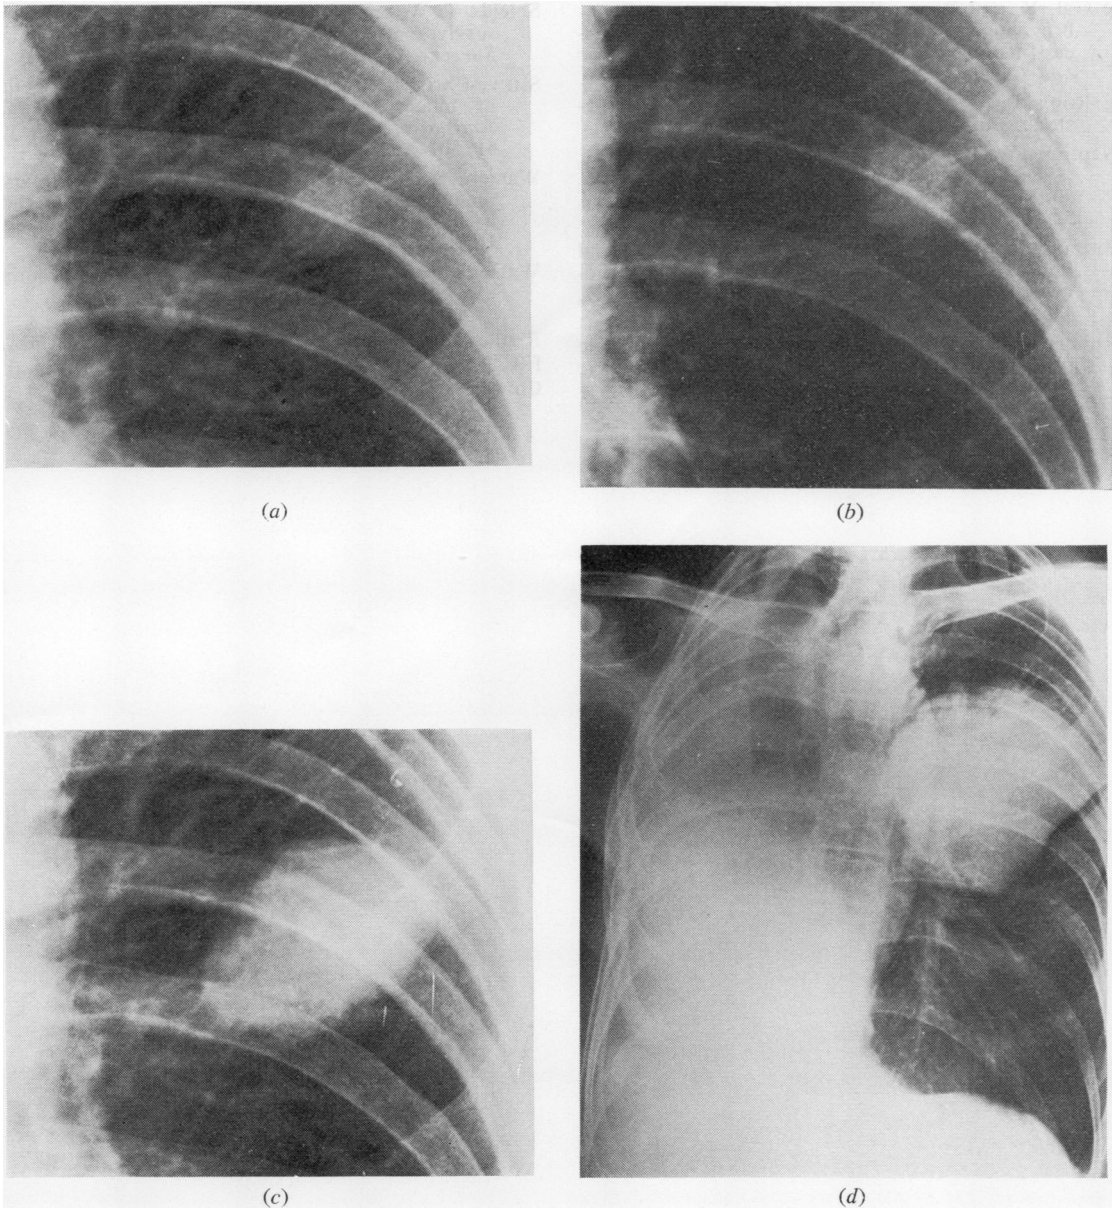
(a) Case 2. Detail of left upper zone of chest radiograph in 1970. The shadow was first visible in 1969. (b) Appearance in 1972. (c) Appearance in 1973. (d) Appearance in May 1975 (compare size with Fig. 4d).
